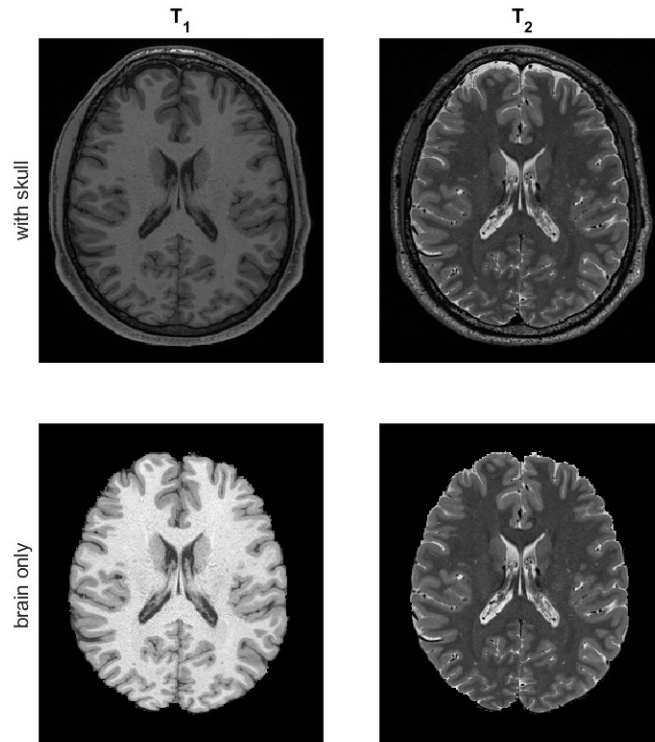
Comparison between T_2 (left) and T_1 (right) images obtained from an MRI from dataset in (Glasser et al., 2013). The main difference in these two images can be seen in the color intensities between the gray and white matters.
